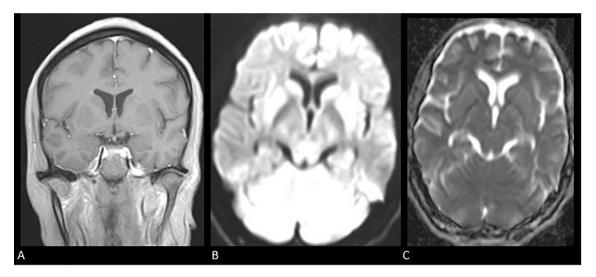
Coronal post contrast MRI showing no enhancement (A); axial DWI sequence showing hyperintense lesion in bilateral basal ganglia region (B); and axial ADC showing no fluid restriction in Bipallida; region (c).
